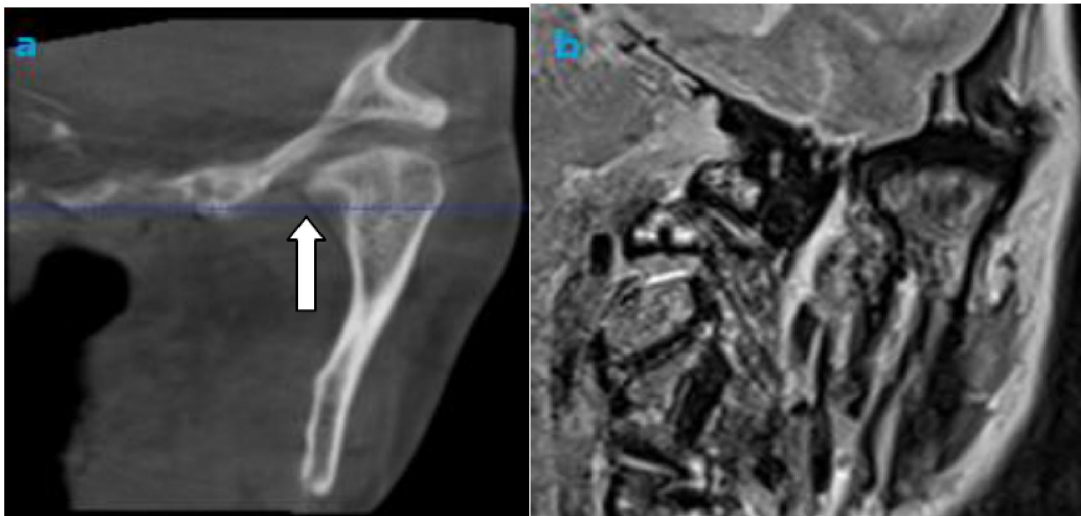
A 30-year-old woman with a history of rheumatoid arthritis for 7 years and a chief complaint of clicking of the left TMJ, (a) the cone beam CT image revealed osteophyte in the left condylar head (arrow), whereas (b) while on the corresponding coronal T2-weighted MR image no abnormality was noted (arrow).
